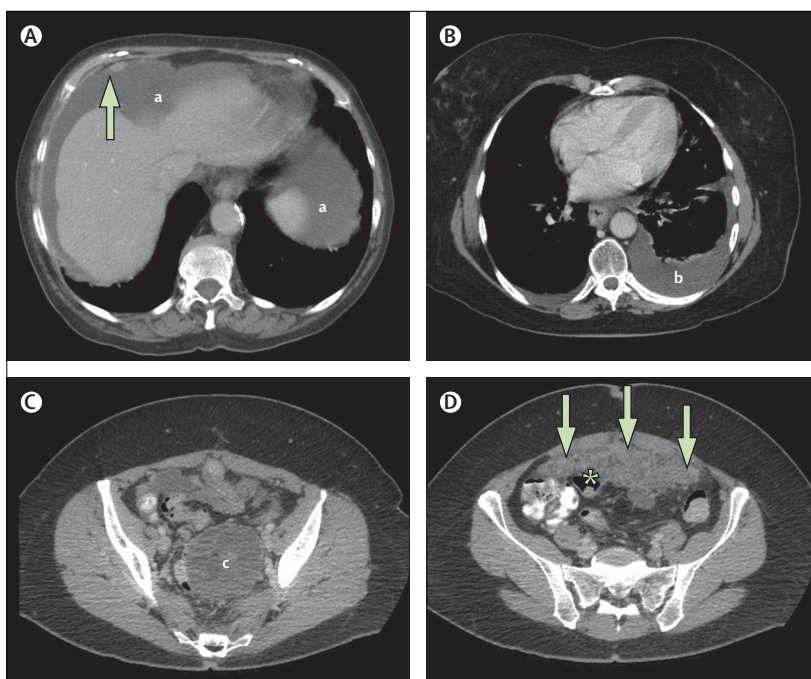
Common CT findings in advanced ovarian cancer
